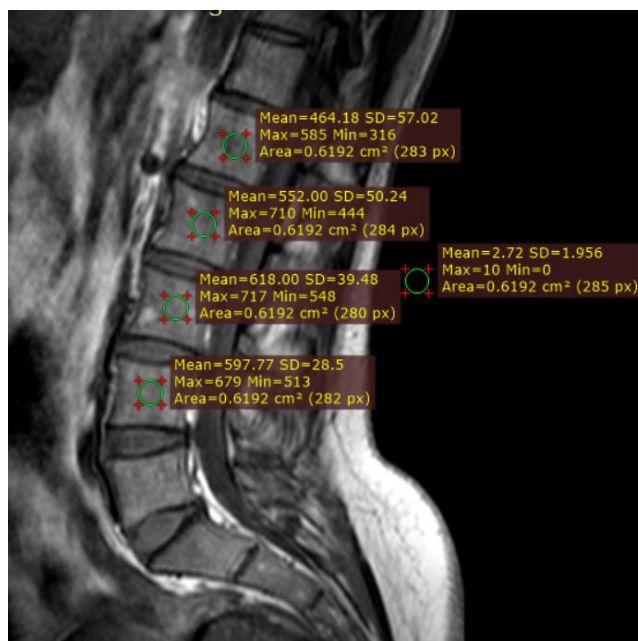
Measurement of signal and noise in the T1-weighted image at L1-4 of the lumbar spine. Min, minimum; Max, maximum; SD, standard deviation.
